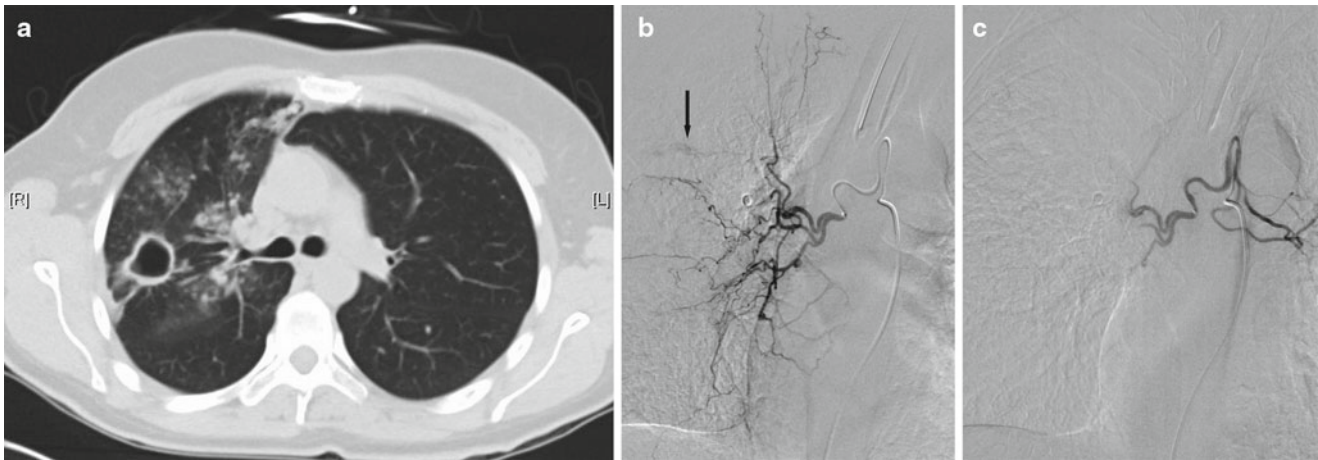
A 46-year-old woman presented with fever, cough, and massive hemoptysis with rapidly progressive hypoxemic failure. The patient required endotracheal intubation, and a bronchoscopy demonstrated a large *right* mainstem bronchus blood clot. The patient stabilized with mechanical ventilatory support and was taken for a chest CT scan which demonstrated a cavitary lesion in the right upper lobe (a). She continued to have small amounts of blood from her ETT, and she was taken for BAE. Bronchial artery arteriography failed to demonstrate diffuse
